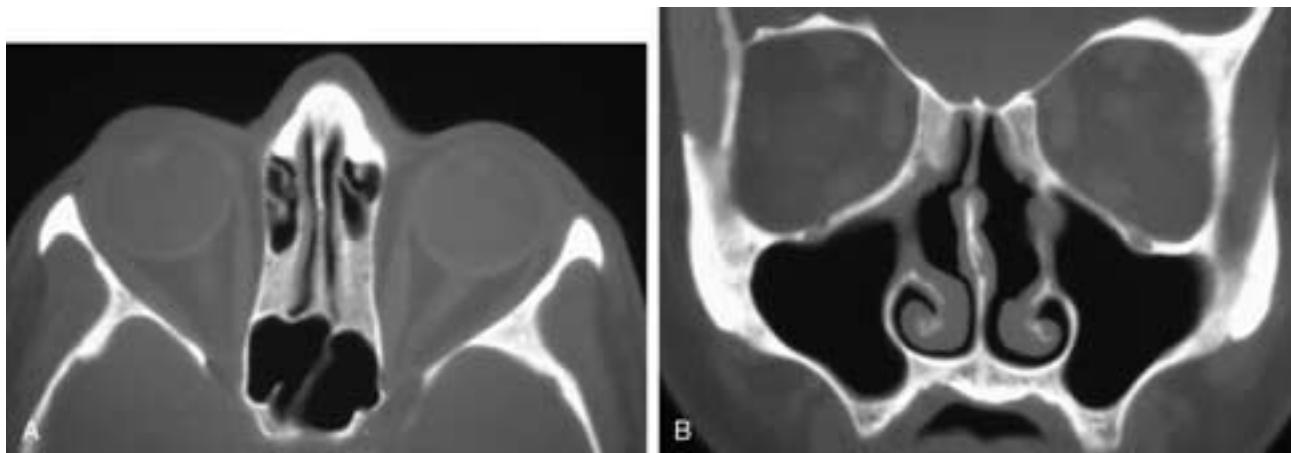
Axial (A) and coronal (B) CT scans on a patient who has had bilateral internal ethmoidectomies. “Ground glass”-appearing bone is present in the upper posterior and middle postoperative cavities, partially obliterating the postoperative ethmoid cavities. This is a normal postoperative bony reactive change and should not be misinterpreted as an abnormality.
